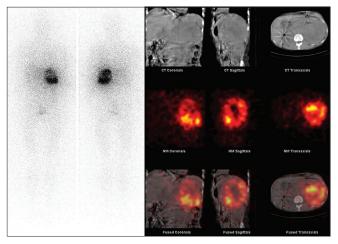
A 40-year-old female, known case of hypertension and type 2 diabetes mellitus presented with an adrenal mass. Urinary VMA was elevated. CECT abdomen showed a large left adrenal region mass with cystic areas. Iodine-131 metaiodobenzyl guanidine (MIBG) whole body scintigraphy and single photon emission computed tomography/computerized tomography showed MIBG avid functioning left adrenal neuro-endocrine tumor. The patient was operated upon and the mass excised and was proven to be cystic pheochromocytoma
